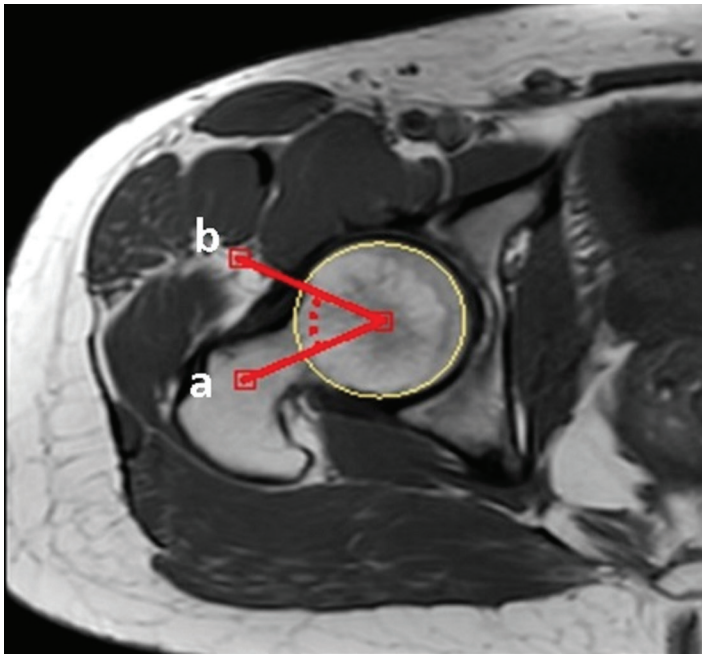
Measurement of alpha angle on oblique axial T1-weighted MR images parallel to the axis of the femoral neck. A circle, which was drawn out-lining the femoral head, the first line from the center of the femoral head down to the long axis of the femoral neck (line a) and the second line from the center of the femoral head to the anterior point where the head extends beyond the margin of the circle (line b)
